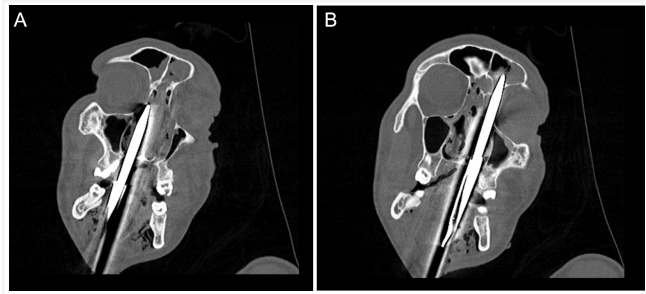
(A, B) Maxillofacial computed tomography image of the patient. While the tip of the harpoon on the right was confined to the right nasal cavity, it was observed that the tip of the harpoon on the left entered the frontal sinus on the left.
